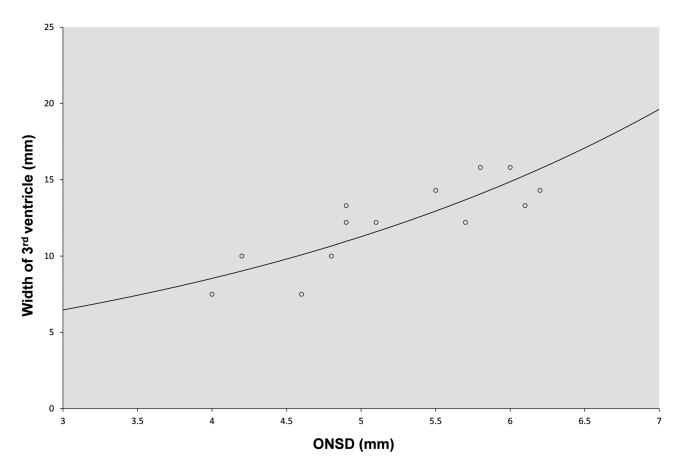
Correlation between the width of the third ventricle measured by transcranial sonography and the ONSD in the same patient.
